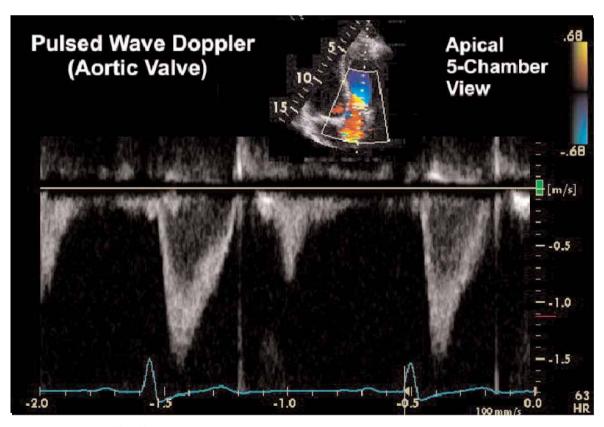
Pulsed-wave Doppler interrogation at the level of the aortic valve.
